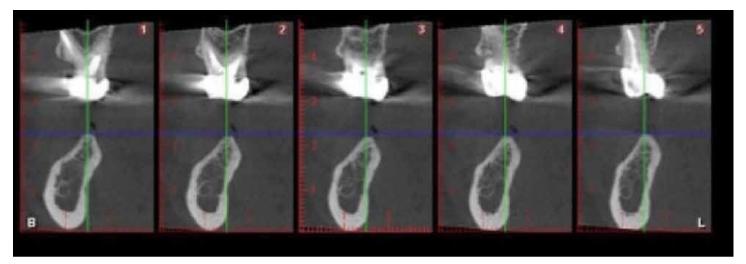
CBCT scans of the implant site.
